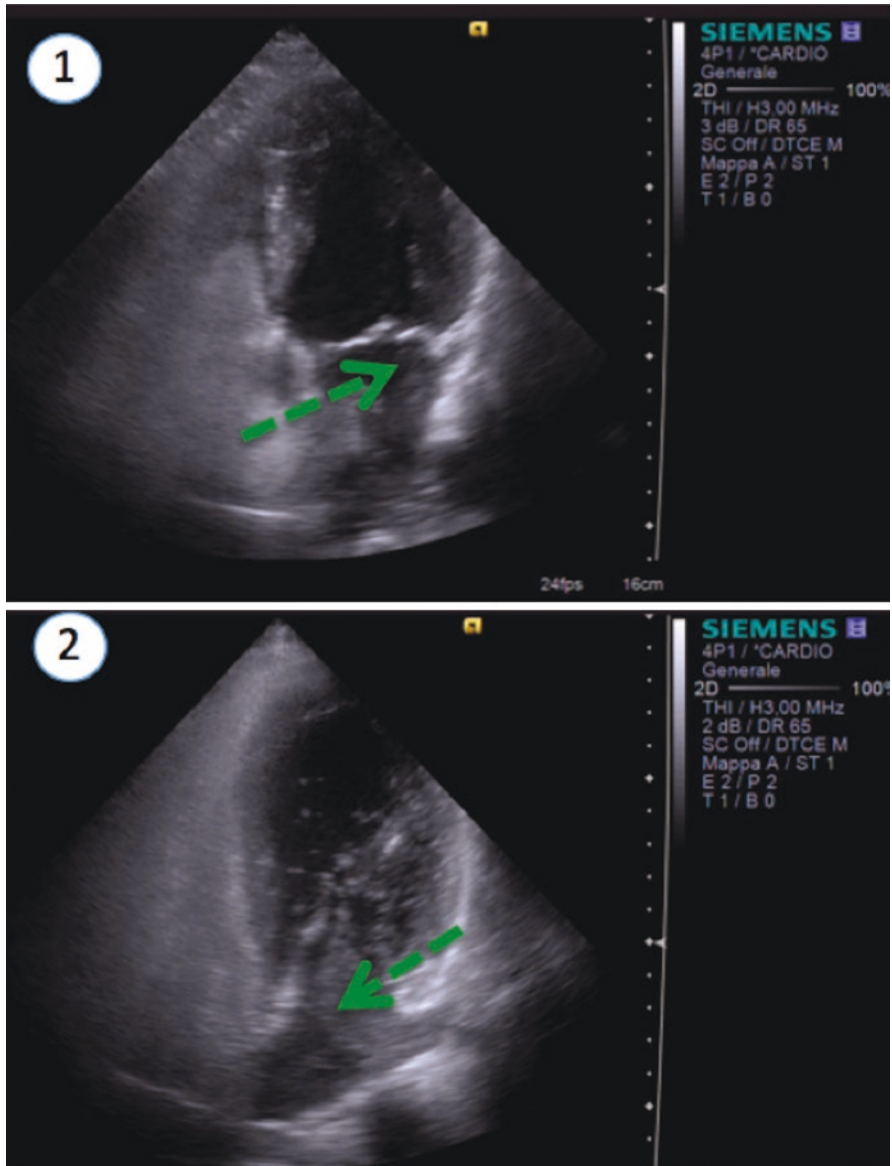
Trans-thoracic echocardiography to discriminate cardiac and pulmonary shunt. TTE shows the passage of the microbubbles within the 3rd heart beat from contrast arrival in the right heart section in PFO, and later when arising from pulmonary veins and pulmonary fistulae. Note the different origin of the bubble jet in the PFO (1), from right atrium, in respect to the pulmonary shunt (2), clearly originating from the pulmonary veins.
